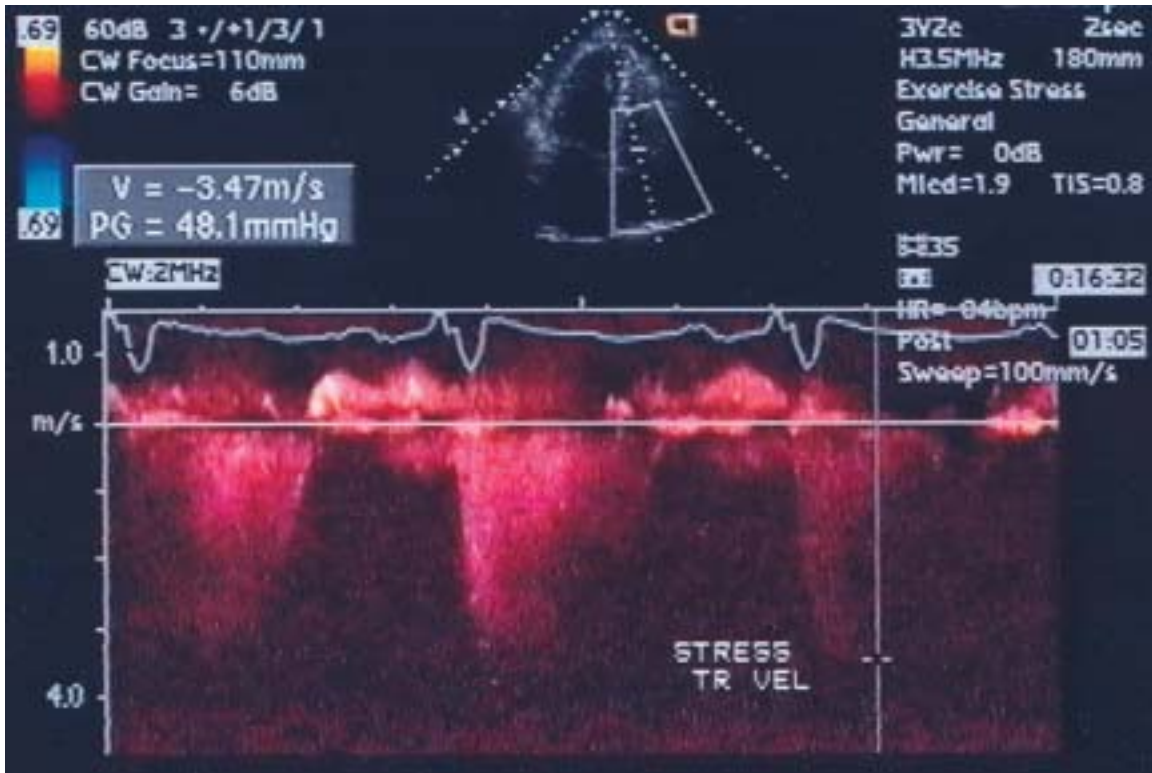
CW Doppler signal of TR velocity increasing to 3.5 m/sec with exercise, RVSP = 48 mmHg.
